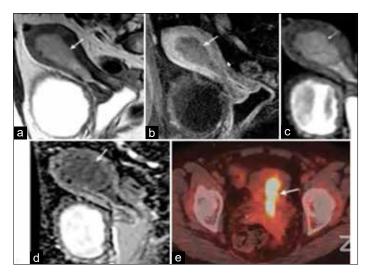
(a) T2 image of Ca endometrium sagittal section. (b) T1 weighted MRI following contrast. (c) Fluorodeoxyglucose. (d) Positron emission tomography. (e) FDG-PET/CT scan
